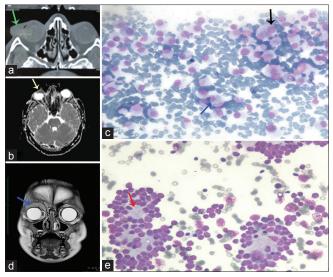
(a) CT Orbit of a case of plasmacytoma showing well defined slightly hyperdense oval soft tissue lesion along the anterolateral temporal aspect of right orbit superiorly (green arrow). (b) MRI Orbit of the same patient when recurrence occurred. A mass located more medially (yellow arrow) than the previous one. (c) Smear showing plasma cells with binucleate (blue arrow) and trinucleate forms (black arrow) (Giemsa, ×400). (d) MRI T2 C+ Coronal Image of metastatic neuroblastoma showing heterogeneously enhancing subperiosteal soft tissue along the outer table of right frontal bone and superior orbital margin (blue arrow). (e) Smear of neuroblastoma showing small round blue cells arranged in rosette pattern (red arrow) (Giemsa, ×400).
